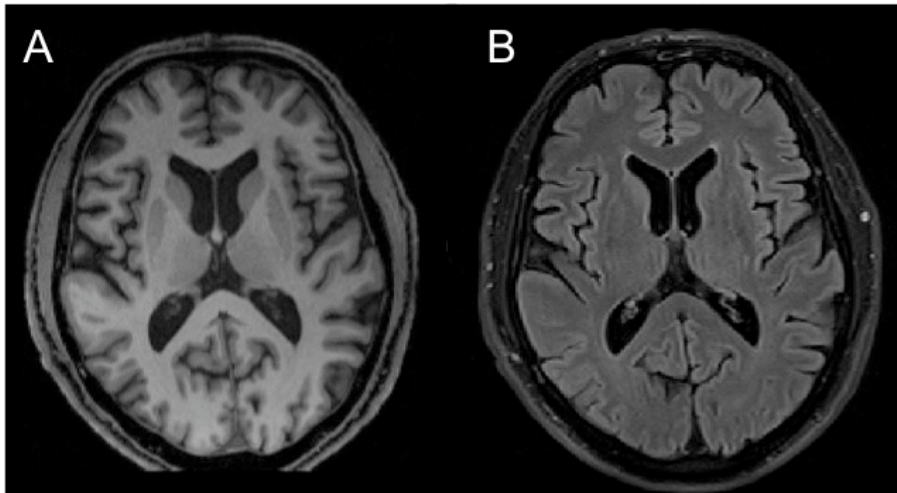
Example images acquired with T1-weighted (A) and FLAIR (B) sequences (from a control subject)
